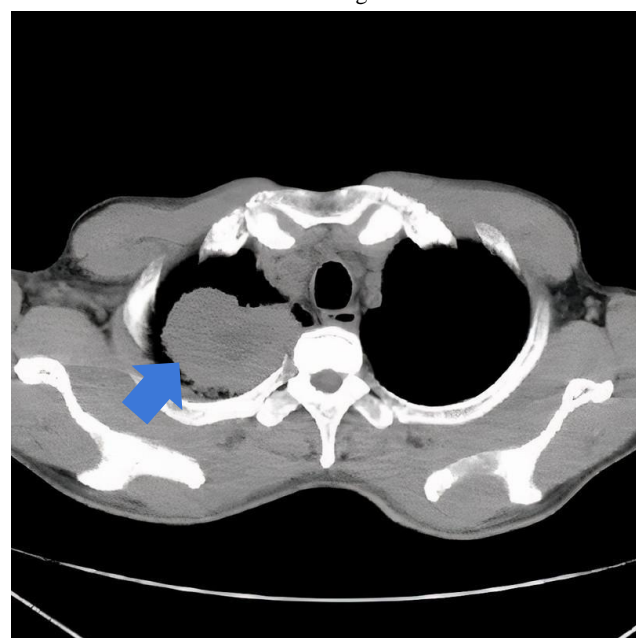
Axial contrast CT-Scan, longest axis of the lesion is 5 cm
